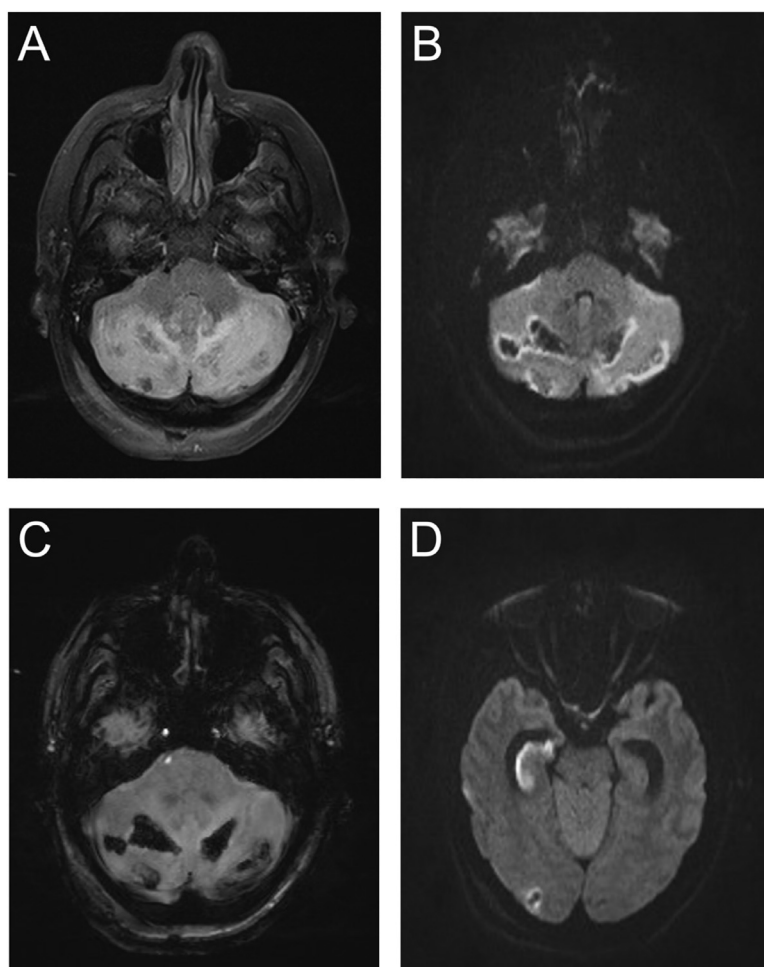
Brain MRI on day 2 status post suboccipital craniectomy and ventricular shunt placement. (A) FLAIR shows extensive bilateral cerebellar edema as well as multifocal isointense to hypointense acute hemorrhages. (B) Axial DWI shows restricted diffusion in the bilateral cerebellar hemispheres. Note signal drops due to susceptibility artifacts of cerebellar hemorrhages. (C) Axial SWI shows multifocal hemorrhages in the cerebellum bilaterally. (D) Axial DWI shows acute cytotoxic edema in the right hippocampus. Note an additional small hemorrhage in the right occipital lobe.
